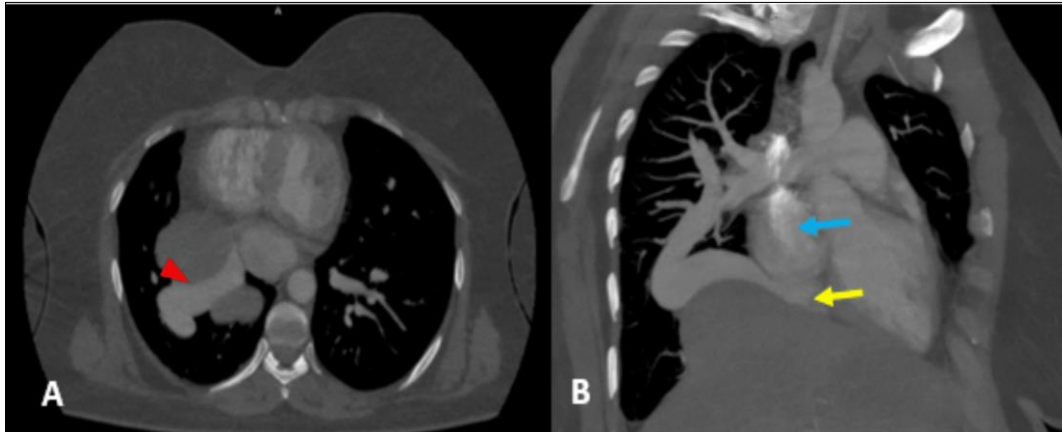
(A): axial slice of a thoracic CT-Angiography showing a dilated right pulmonary vein crossing above the diaphragmatic hernia (red arrow head). (B): coronal image with maximum intensity projection (MIP) of a thoracic CT-Angiography revealing the dilated pulmonary vein joining the IVC (yellow arrow) before its junction with the right atrium (blue arrow)
